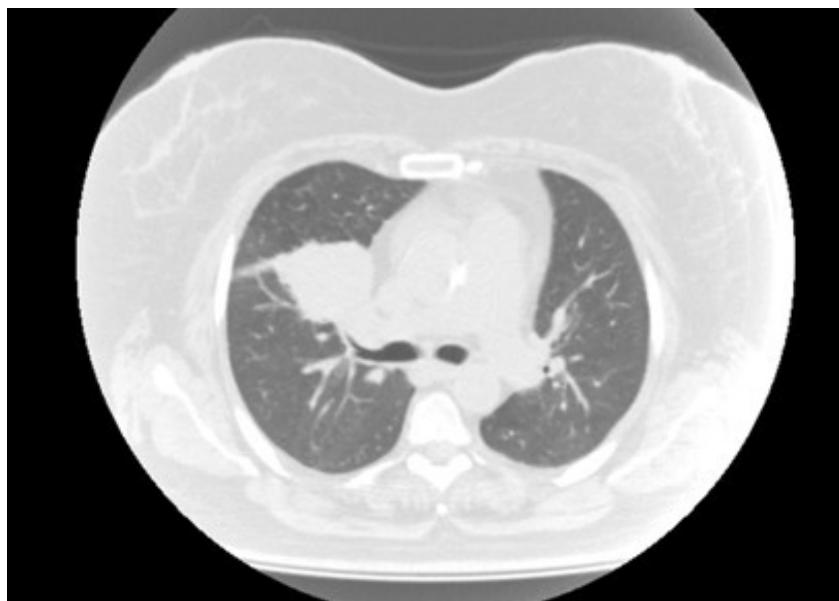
Non-contrast computed tomography (CT) of the chest revealed a 38×42 mm mass lesion.
